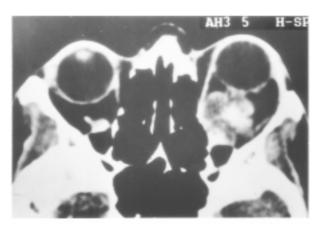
Preoperative CT scan demonstrates homogeneously enhanced multiple lesions in the left orbit (a) and magnified CT showing the relation of the lesion to the medial compartment of the orbit (b)
